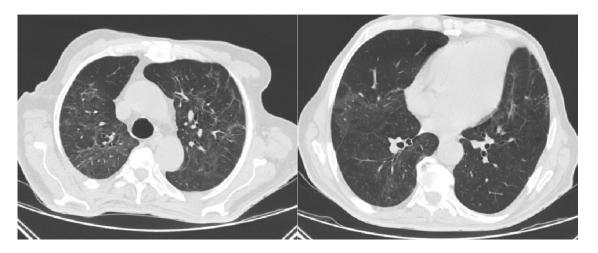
Control chest CT 15 days after steroid initiation. Note the disappearance of consolidation areas with persistence of some ground glass areas.
